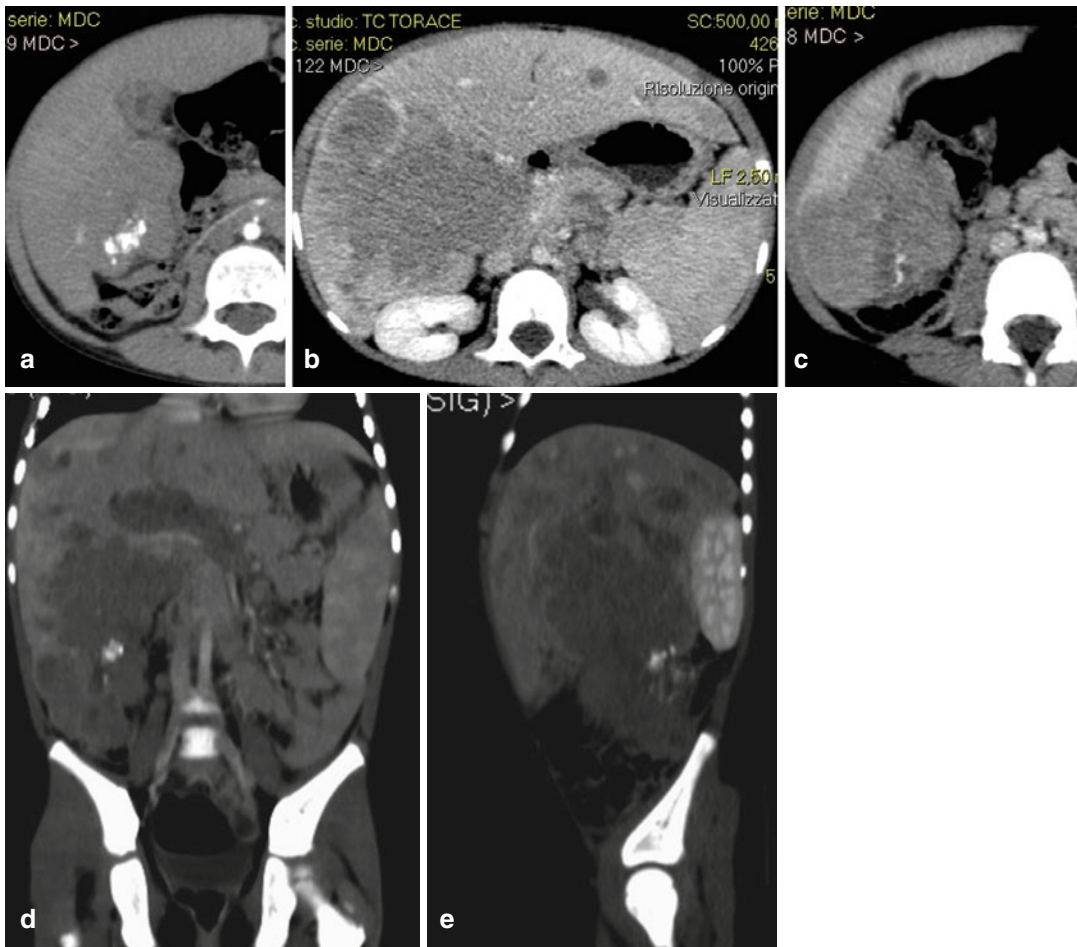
Male, 3 years with abdominal distension and anorexia. Axial CT scan without CE (a) shows a hypodense hepatic area with calcifications. In MDCT scans (b, c) and MPR coronal and sagittal reconstructions
